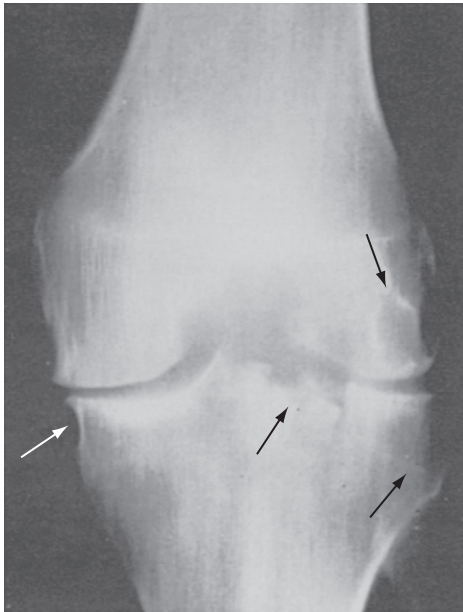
Tuberculous arthritis of the knee. On conventional computed tomography, typical marginal and central osseous erosions (arrows) accompany tuberculous arthritis. Osteoporosis is not prominent. (From Resnick D: *Diagnosis of bone and joint disorders*, ed 3, Philadelphia, 1995, WB Saunders, p 2480.)
